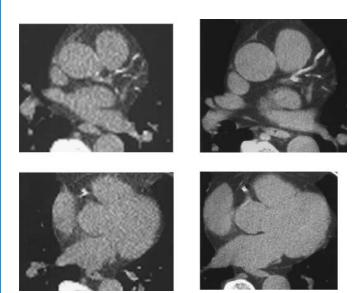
Electron beam computed tomography (left) and helical computed tomography (right) of a 72 year old man. Top, calcium in the left anterior descending coronary artery and circumflex; bottom, calcium in the proximal right coronary artery. Reproduced with permission from Carr et al. (39).
